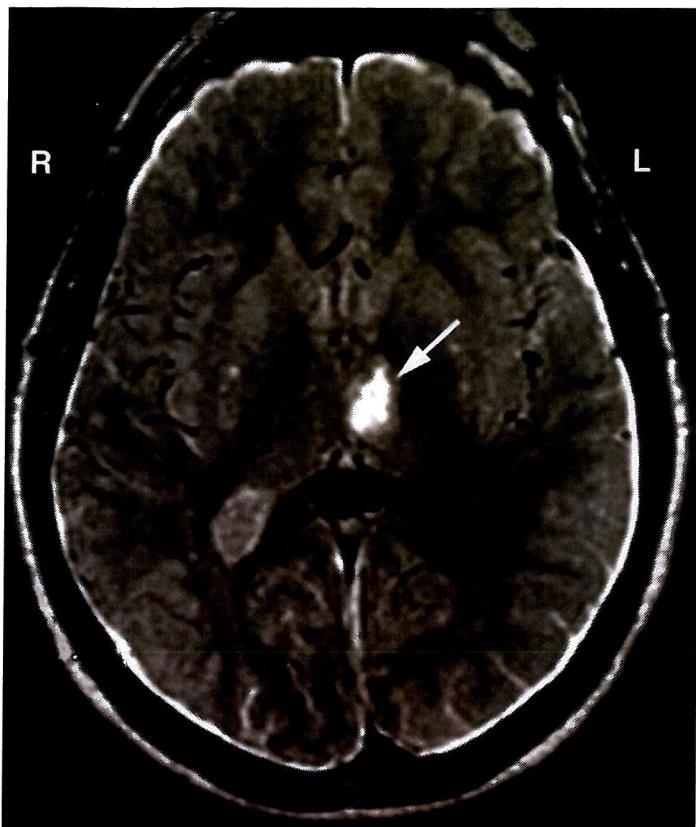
Axial MRI scan of MW's brain showing the left thalamic lesion.
